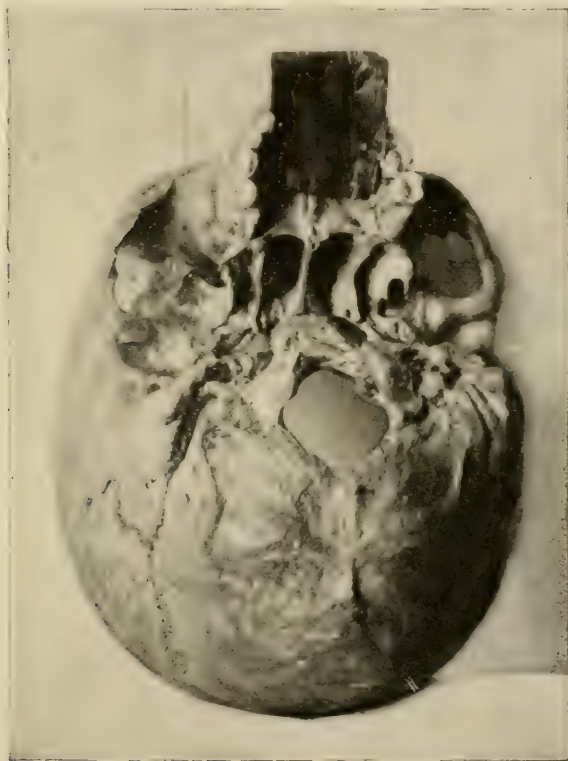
Position of film in the mouth for radiographing upper anterior teeth. See pose Fig. 94.
